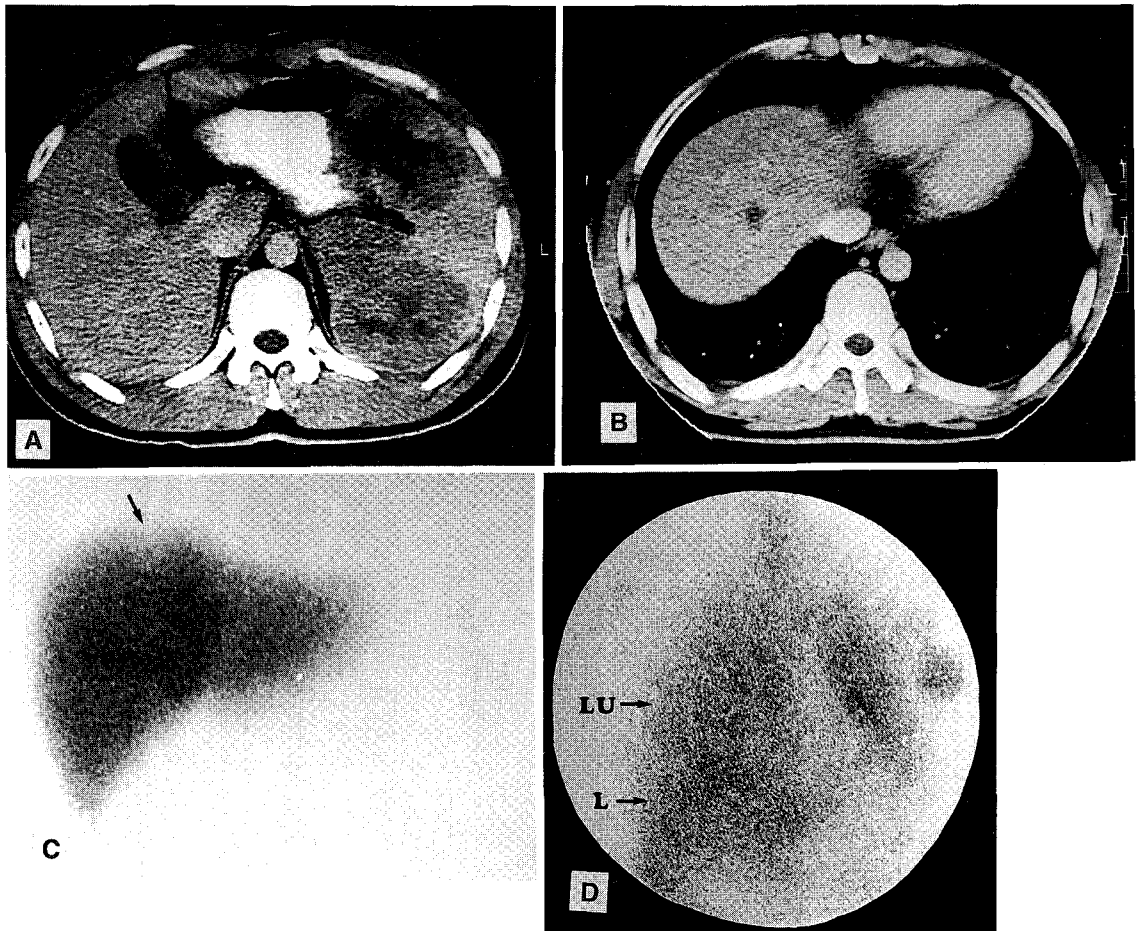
Images of a 31-year-old patient with Non-Hodgkin's lymphoma. (A) CT scan demonstrates the primary lesion involving the spleen. (B) Eight months later, CT scan shows early metastatic lesion in the dome of the right lobe of the liver, which is also shown in the liver scan (C). Ga-67 planar scan of chest and abdomen (D) at this time reveals no abnormal uptake in the liver (L) and spleen area due to diffuse lung uptake (LU) by pneumonitis. There is abnormal lymph node uptake in the left axillary region.
